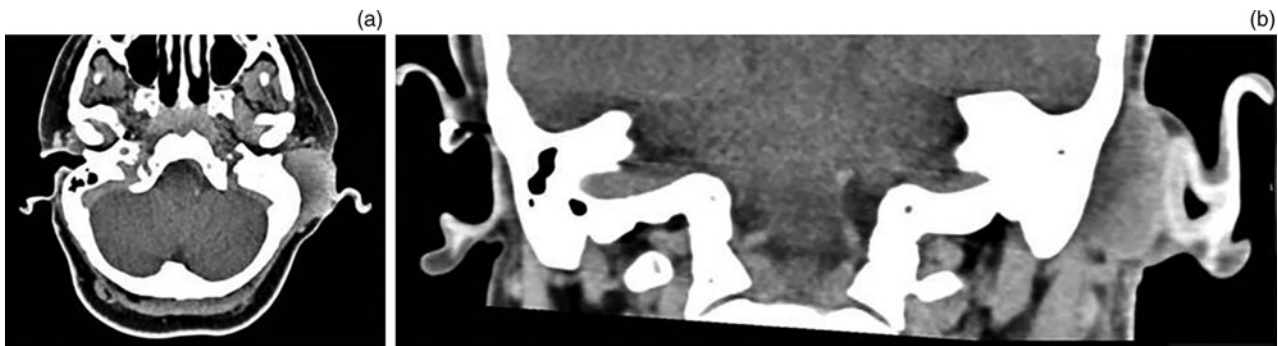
(a) Axial and (b) coronal computed tomography scans with contrast.
